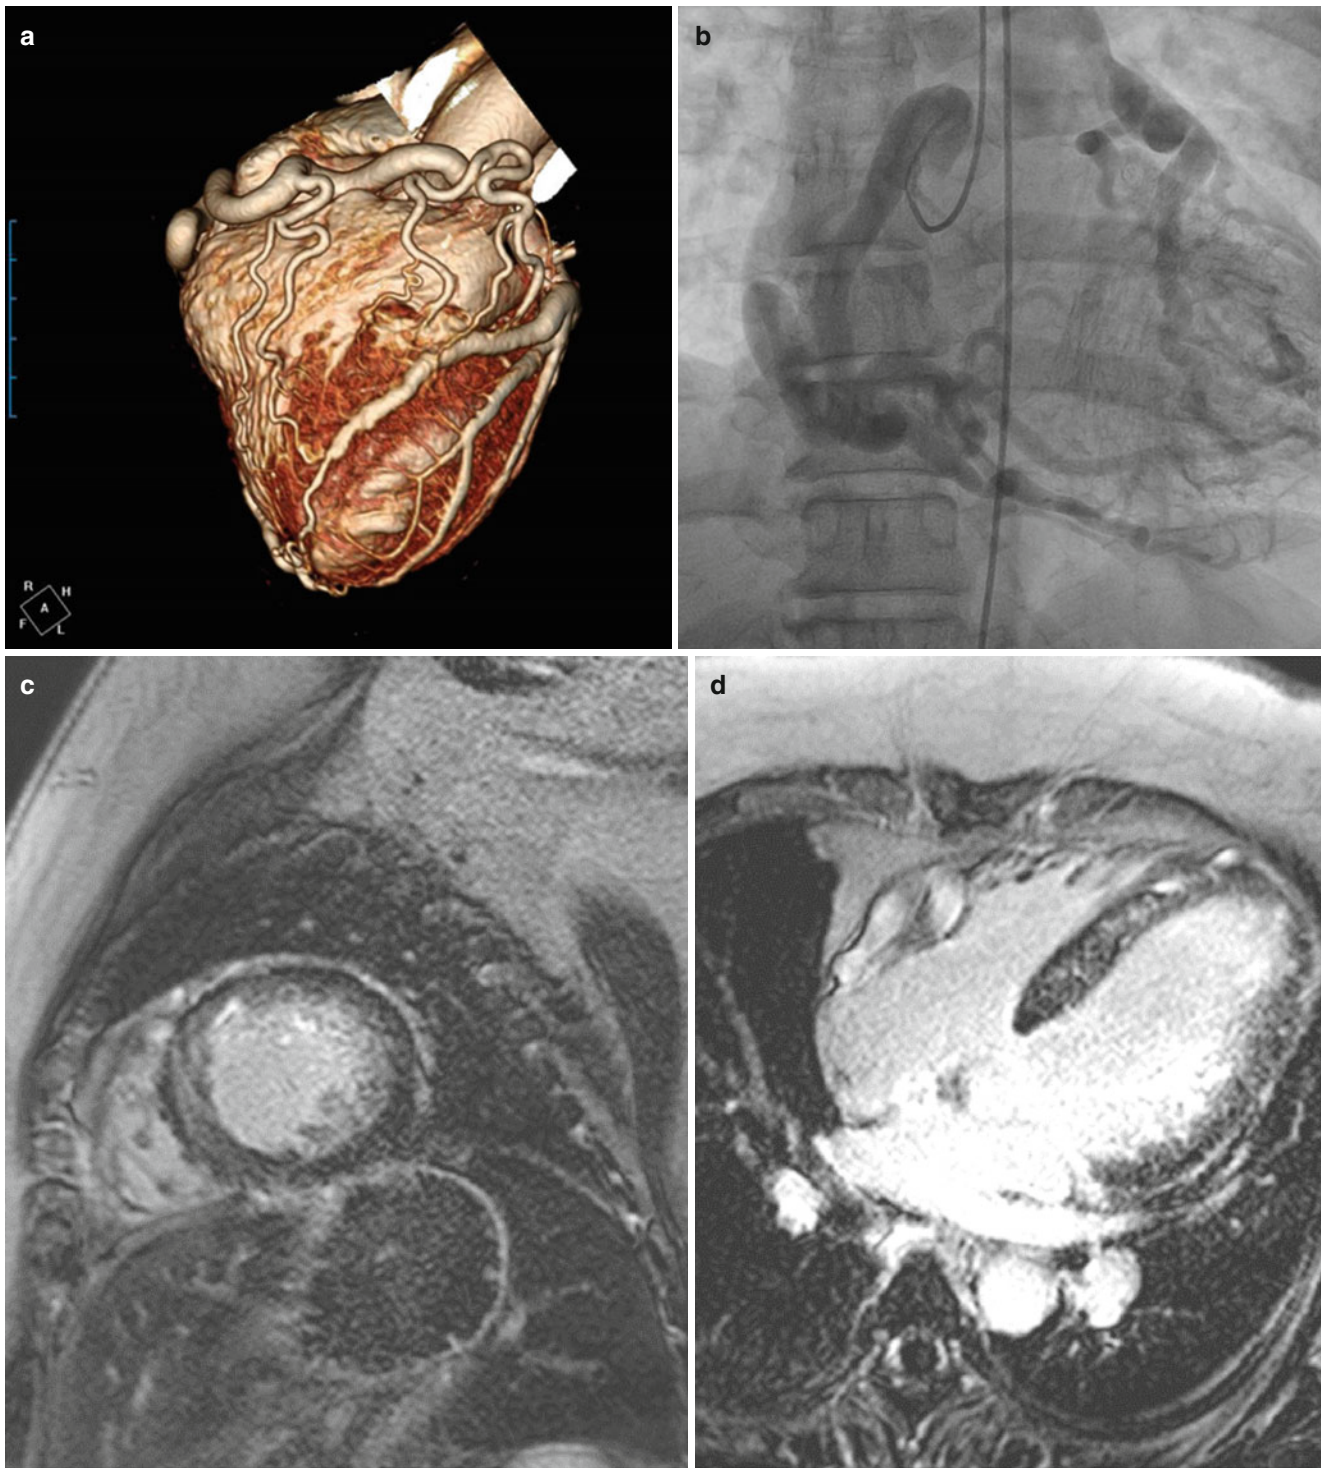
ALCAPA. Right coronary angiography (a) and coronary CTA (b) image show well-developed collaterals from the markedly dilated right coronary artery (RCA) to the dilated and tortuous left coronary artery (LCA) originated from the main pulmonary artery (PA). Delayed
